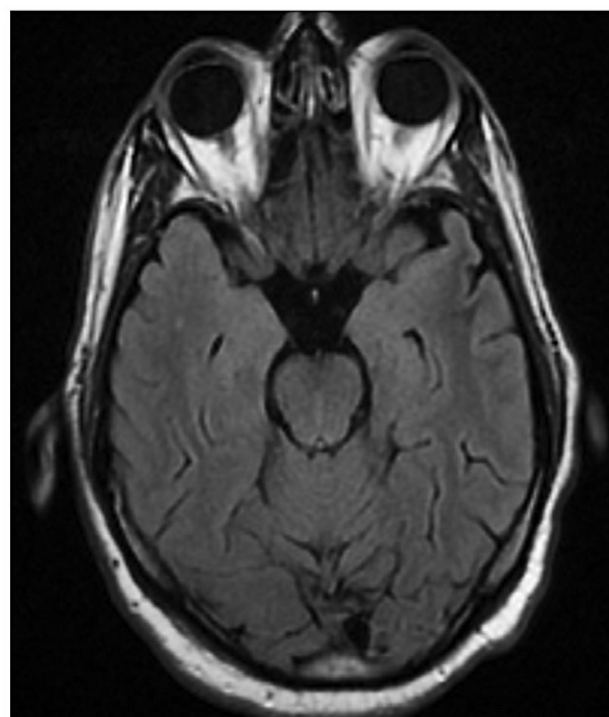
Axial T2 FLAIR in hyperglycemic hyperosmolar state shows hypointensity in the subcortex of the upper left temporal lobe..
